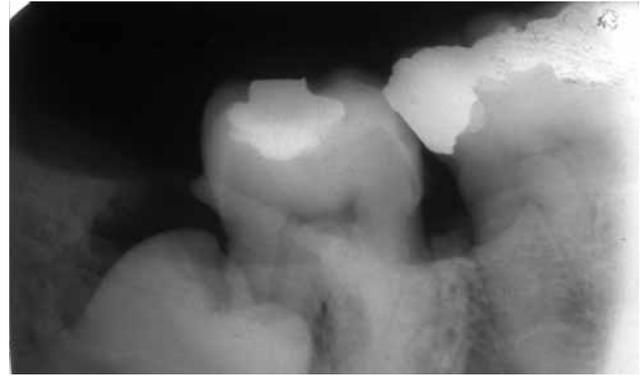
The intraoral radiograph prior to the extraction attempt that does not provide with the necessary information to avoid complications
